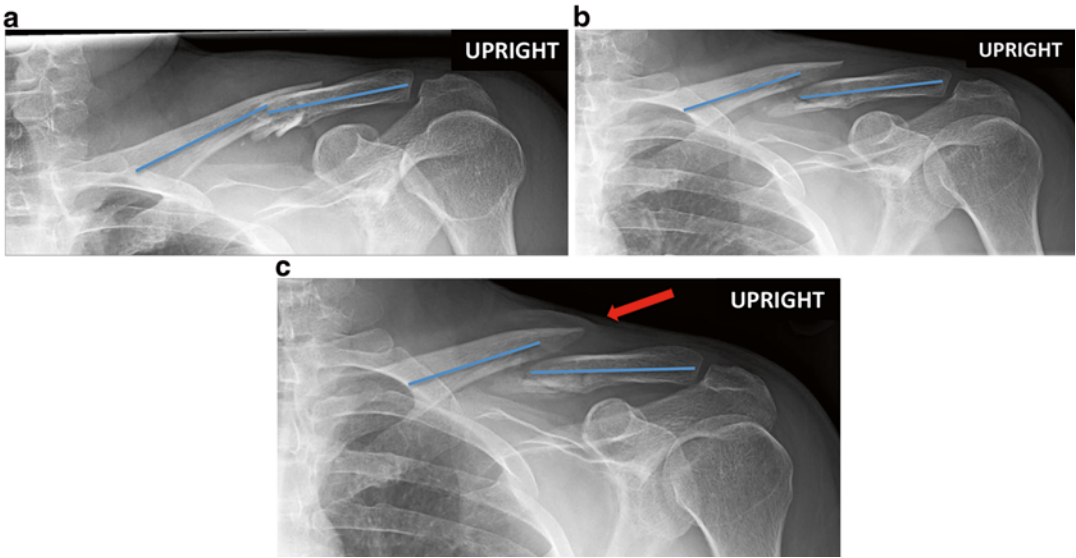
(a) is an X-ray of an injury showing a middle 1/3rd clavicle fracture with minimal angular deformity or medialization. (b) and (c) demonstrate incremental displacement at 7 and 14 days after injury, respectively.
